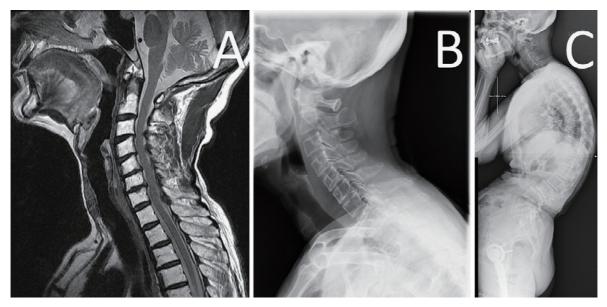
Preoperative images. (A) Sagittal T2-weighted MRI shows multilevel cervical cord compression. (B) X-ray shows cervical lordotic alignment (C2-7 angle, 30°), but the loading axis of the head is anterior (CGH-C7 SVA, 53 mm), which means that there was cervical sagittal imbalance. (C) Standing lateral X-ray shows marked thoracic kyphosis (Th5-Th12, 58°). As a compensation, there is hyperlordosis in the cervical and lumbar spine.
